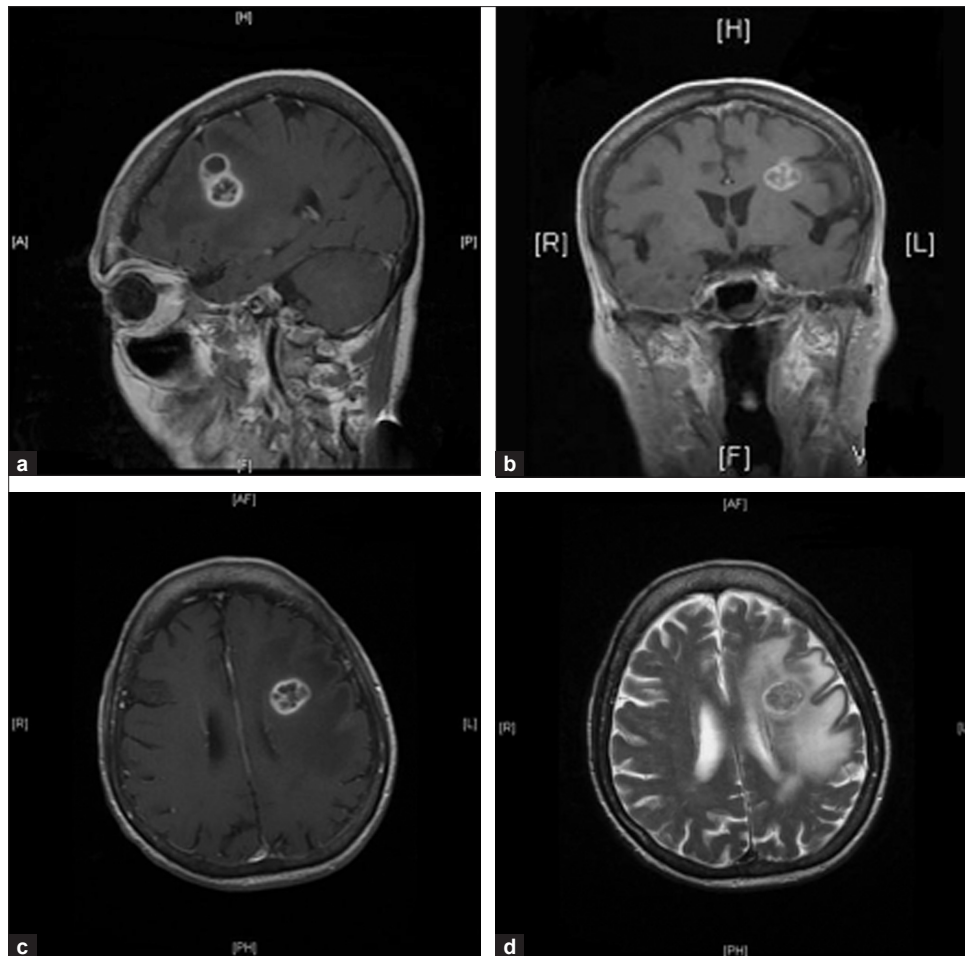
Cranial, sagittal and axial T1 weighted images demonstrating a 25 × 18 × 10 mm complex, lobulated, enhancing mass on post-gadolinium centered within the left frontal lobe. T2-weighted images demonstrate associated extensive vasogenic edema and mild mass effect.
